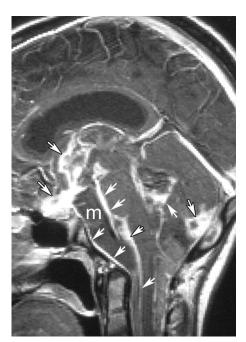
Dissemination from a pilocytic astrocytoma following resection. Contrast-enhanced sagittal T1-weighted image of the brain shows diffuse enhancement (arrows) of the basilar cisternal spaces, with extension into the upper cervical spine. A cystlike mass (m) is seen anterior to the brainstem.
